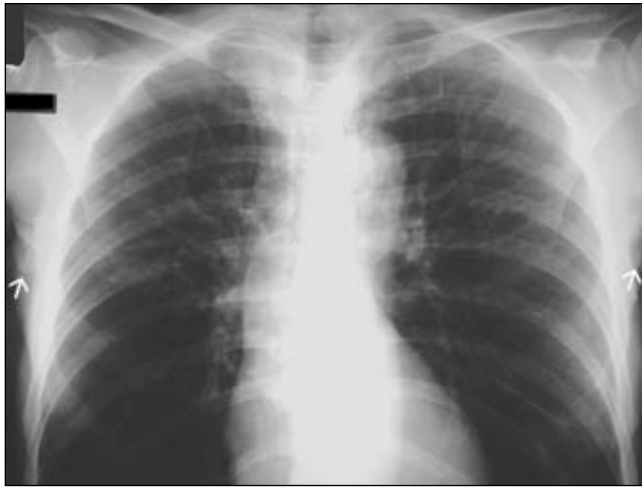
Plain chest radiograph showing emphysematous changes predominantly in the lower lung zones and the tortuosity of the aorta. Note the sagging, redundant folds of skin in the patient's axillae (arrows)
